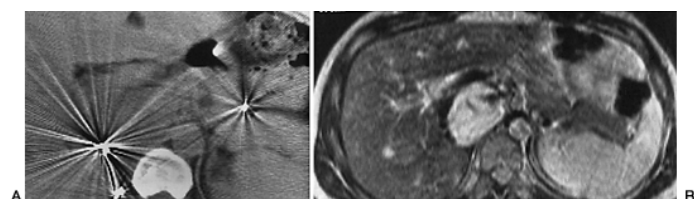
18. The advantage of magnetic resonance imaging (MRI) in detecting retroperitoneal lesions when multiple surgical clips are present. This patient had resection of adrenal carcinoma several years before. A: Multiple clips obscure the retroperitoneum on this precontrast computed tomography (CT) scan. B: T₂-weighted image demonstrates a recurrence adjacent to the inferior vena cava. The MRI is less influenced by surgical clip artifact than is the CT.
